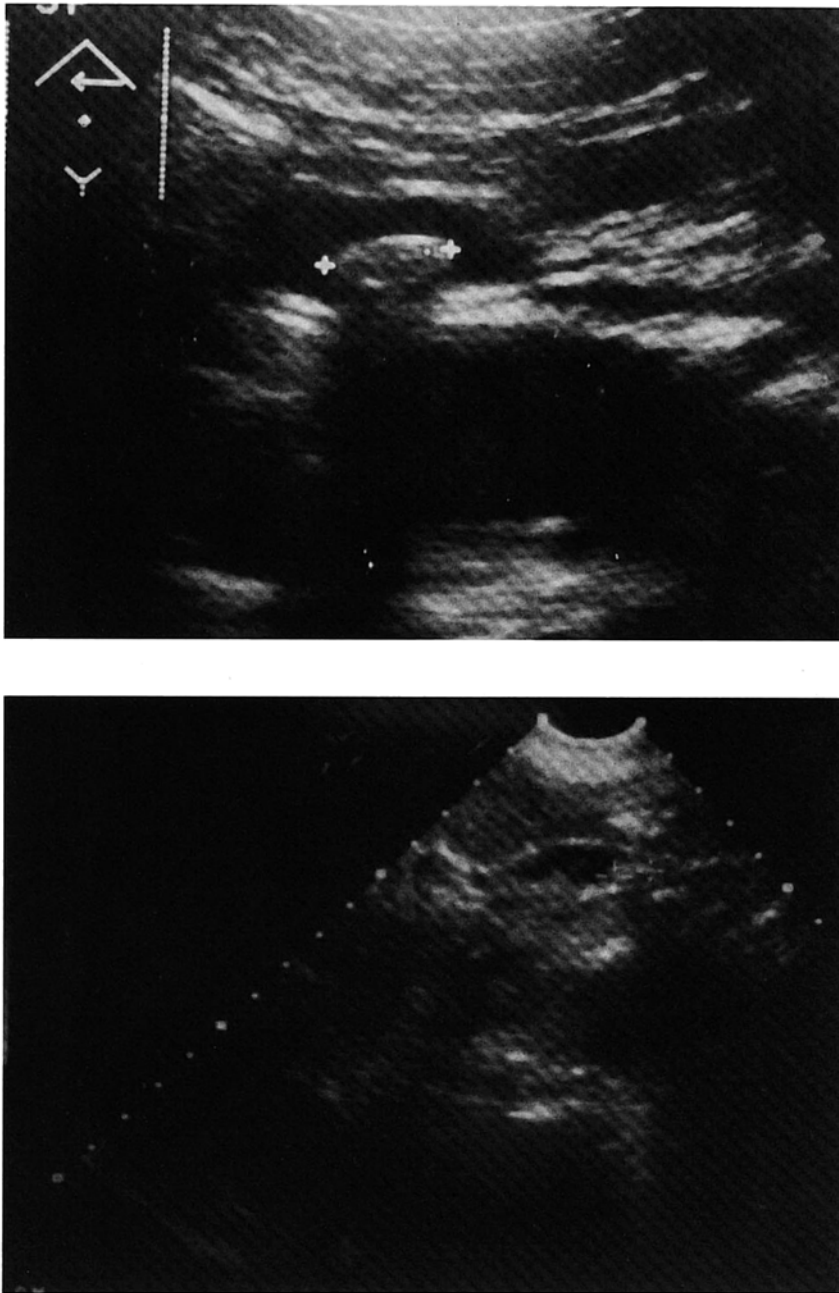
Top: Ultrasonographic scan of the stone (2.2 cm) located in the middle portion of the common bile duct. Pre-ESWL using the Dornier MPL 9000. Bottom: Ultrasonographic image after lithotripsy shows the remaining fragments in the common bile duct.
